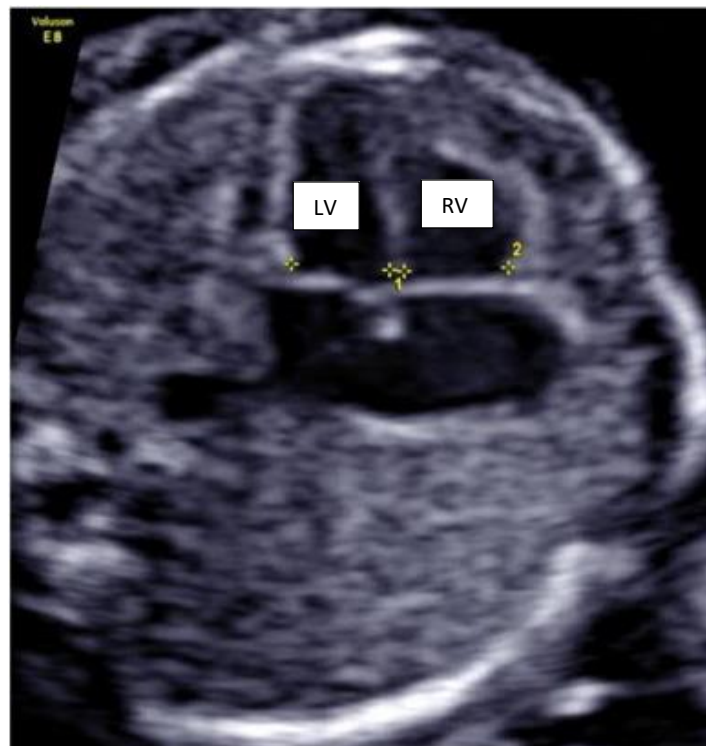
Echocardiographic four-chamber view demonstrating foetal ventricular disproportion in a foetus with suspected CoA. The LV appears subjectively narrower in width compared with the RV. (Image obtained with consent).
